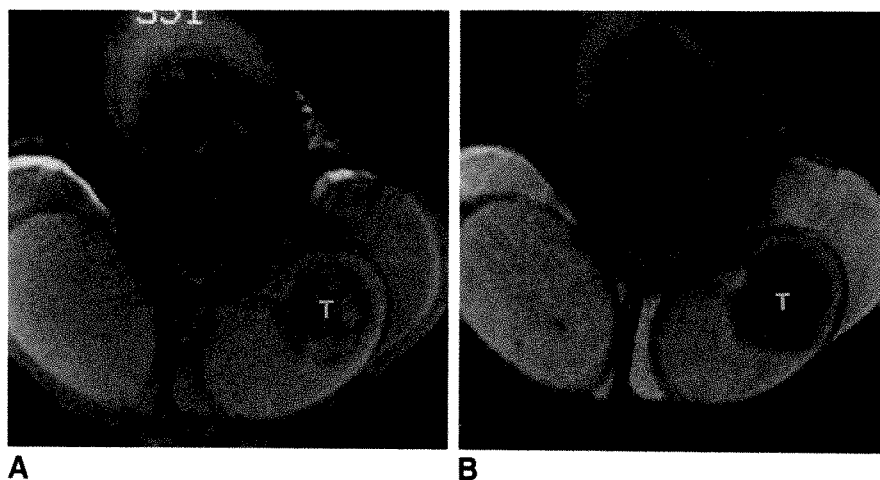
Teratocarcinoma (T) of left testis. A, Proton-density MR image, 2000/20, shows heterogeneous signals. B, T2-weighted image, 2000/70, second echo of A, shows further increase in signal heterogeneity compared with normal testicular tissue of ipsilateral and contralateral testes. Although this lesion is predominantly darker than testis on T2-weighted image (B), note that unlike seminomatous lesions, this lesion is darker than testis on proton-density image (A) and heterogeneous on T2-weighted image (B). Note bilateral hydrocele.
